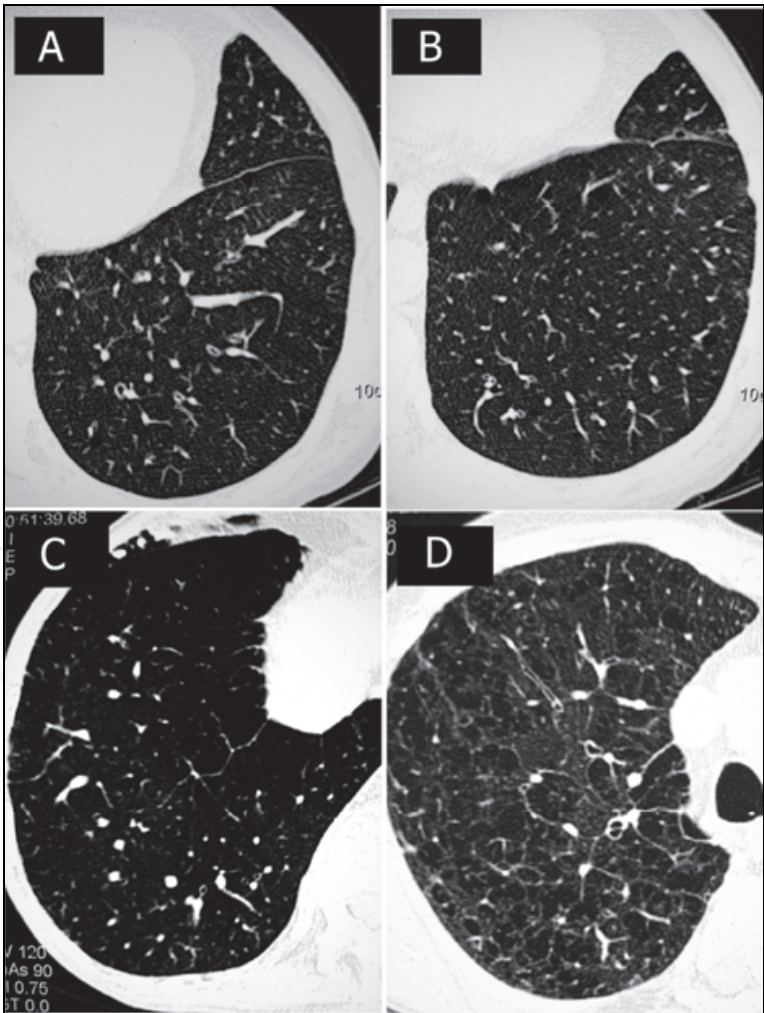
HRCT axial scans showing directly visible small airways as (A-C) air filled ring like structures and (D) air filled branching tubular structures.
